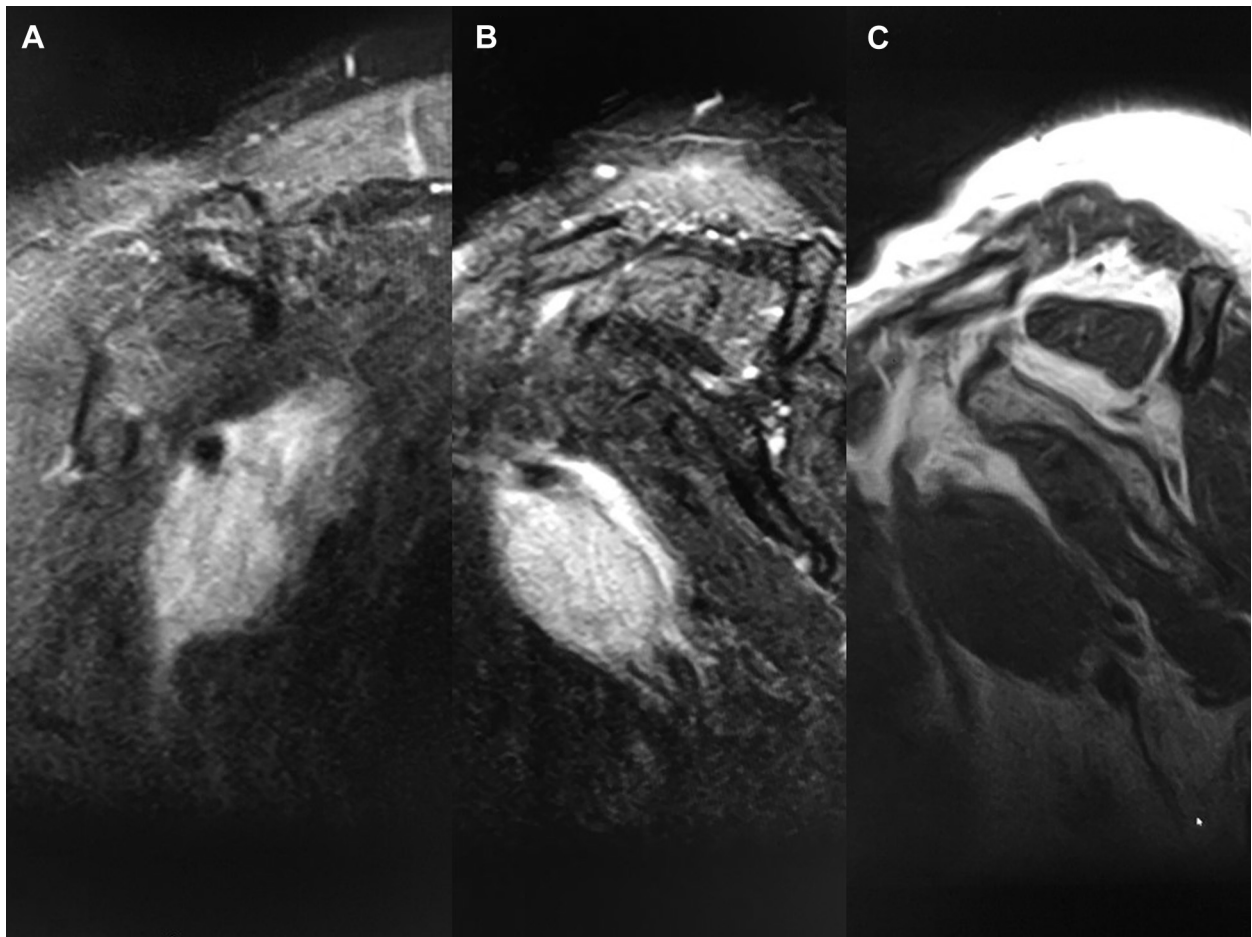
The noncontrast magnetic resonance imaging (MRI) of the shoulder demonstrate heterogenous, solid mass with hyperintense signal on sagittal (A), and coronal fat-saturated T2-weighted (B) sequences and hypointense signal on T1-weighted sequence (C).
